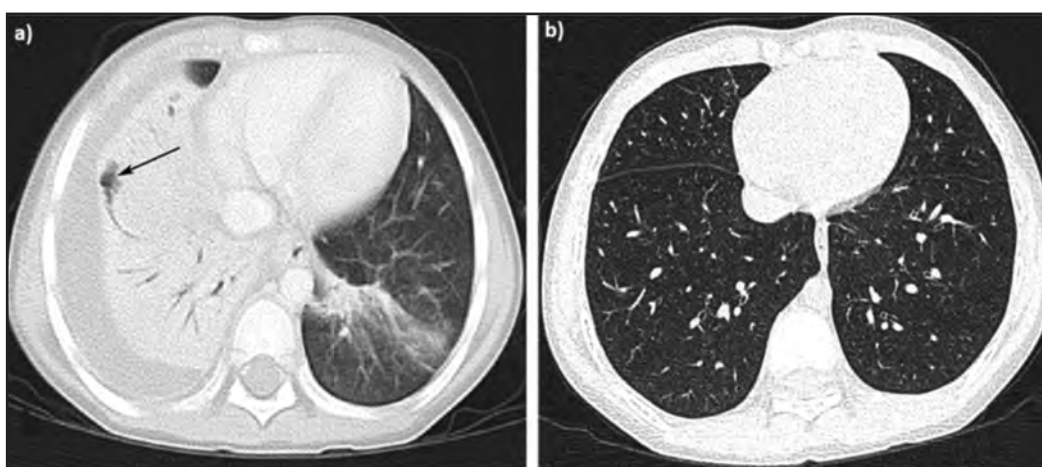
CT-scan of the thorax at a) age of 5 years shows a collapsed consolidation with pleural effusion of the right lower lobe with a focal bronchiectatic changes at the periphery (black arrow), b) 3 months after the start of subcutaneous immunoglobulin therapy shows complete resolution of the consolidation, bronchiectasis and pleural effusion. The lung parenchyma is normal.
